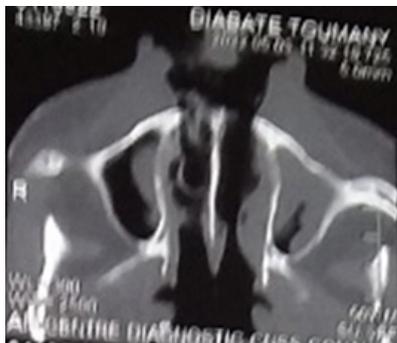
The CT scan of the facial mass showed bone and cartilage lysis, irregular thickening of the nasal pyramid, continuity of the nasal septum.
